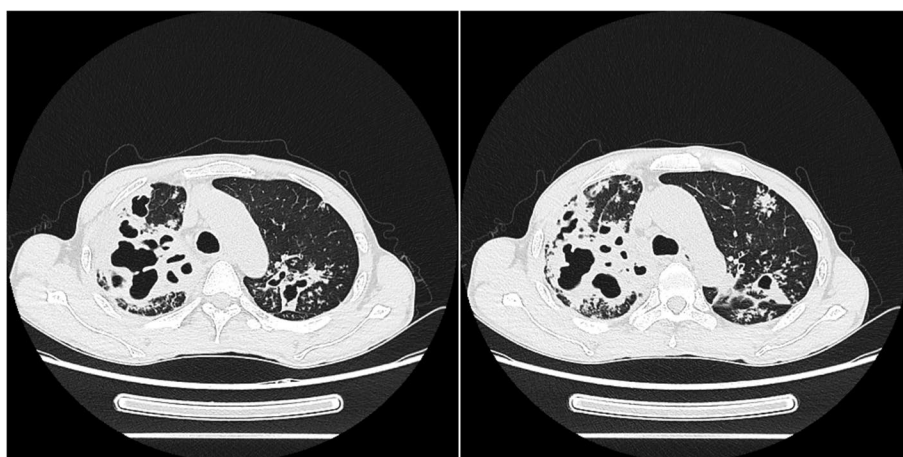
The chest CT scan reveals areas of patchy consolidation and cavitation
